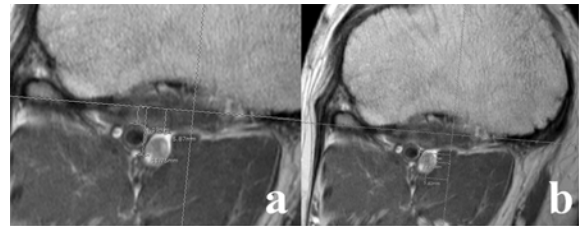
(a) Axial MRI of the knee showing the anteroposterior distance of the popliteal artery, popliteal vein and tibial nerve to the posterior bony aspect at joint line level; (b) Axial MRI of the knee showing the mediolateral deviation of the popliteal artery, popliteal vein and tibial nerve to the PCL stump.
